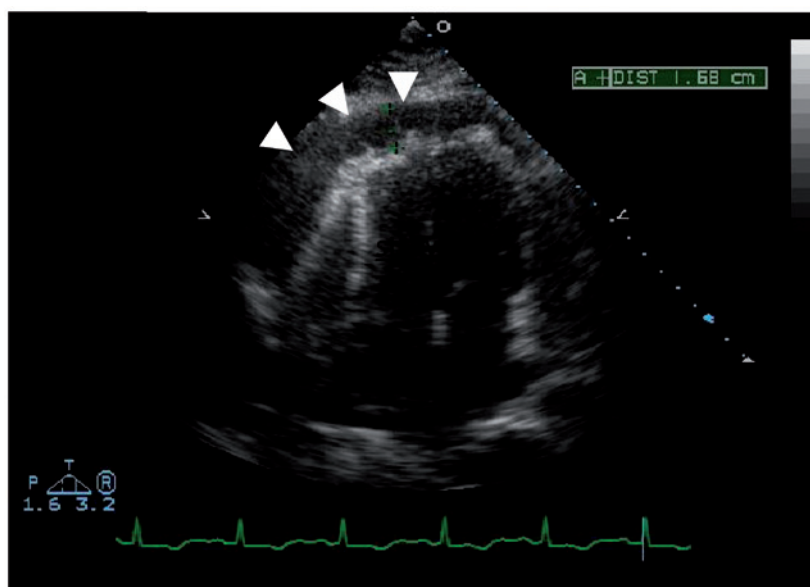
Transthoracic echocardiography showing a thickened pericardium with the presence of severe pericardial effusion (arrowheads), but no evidence of cardiac tamponade. The left ventricular function and cardiac valves were normal.
